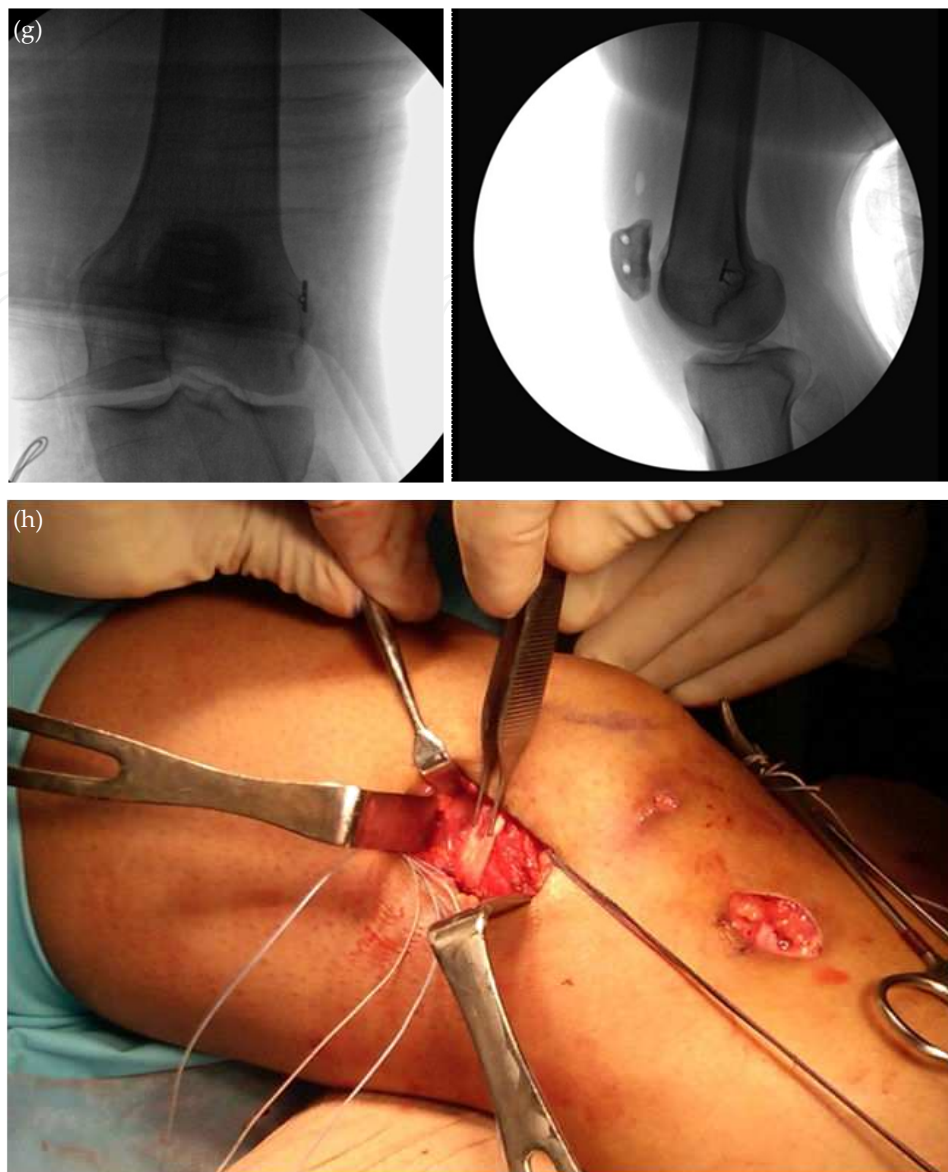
MPFL reconstruction with a double incision technique, using semitendinosus autograft, interference screws/knotless anchors on the patella side, and interference screw + cortical suspensory button-loop device on the femoral side. a) guidewires drilled into the medial facet of the patella; note the incision for semitendinosus harvest; b) position of the guidewires confirmed radiographically; c) semitendinosus graft secured to the patella; d) intraoperative lateral image showing a radiographic template overlying the distal femur, allowing placement of the guidewire in the appropriate position for a femoral tunnel; e) femoral tunnel is reamed under fluoroscopic visualization; f) graft is passed to the femoral tunnel; g) intraoperative radiographs (AP and lateral) of the final reconstruction, demonstrating patella tunnels and the suspensory button-loop fixation device on the lateral femoral cortex; h) intraoperative photograph of the final reconstruction (different case – single incision technique, with gracilis autograft)
